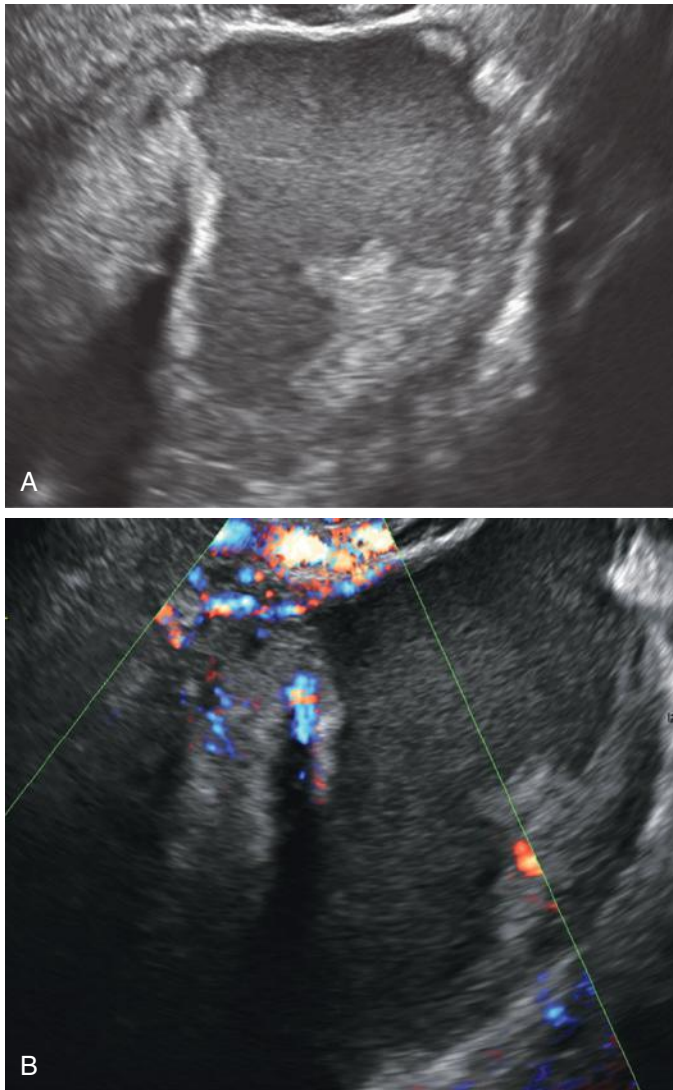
Decidualized endometrioma. A, Cystic ovarian mass in a pregnant patient contains diffuse homogeneous low-level internal echoes with an irregular solid-appearing peripheral component. B, Color Doppler imaging shows blood flow within the solid area, a finding that is often considered worrisome for malignancy. At surgery, this mass proved to be a decidualized endometrioma. (From Benacerraf BR, Goldstein SR, Groszmann YS: Endometriosis. In Benacerraf BR, Goldstein SR, Groszmann YS [eds]: *Gynecologic Ultrasound: A Problem-Based Approach*. Philadelphia, Elsevier, 2014, Fig. E4-5.)
